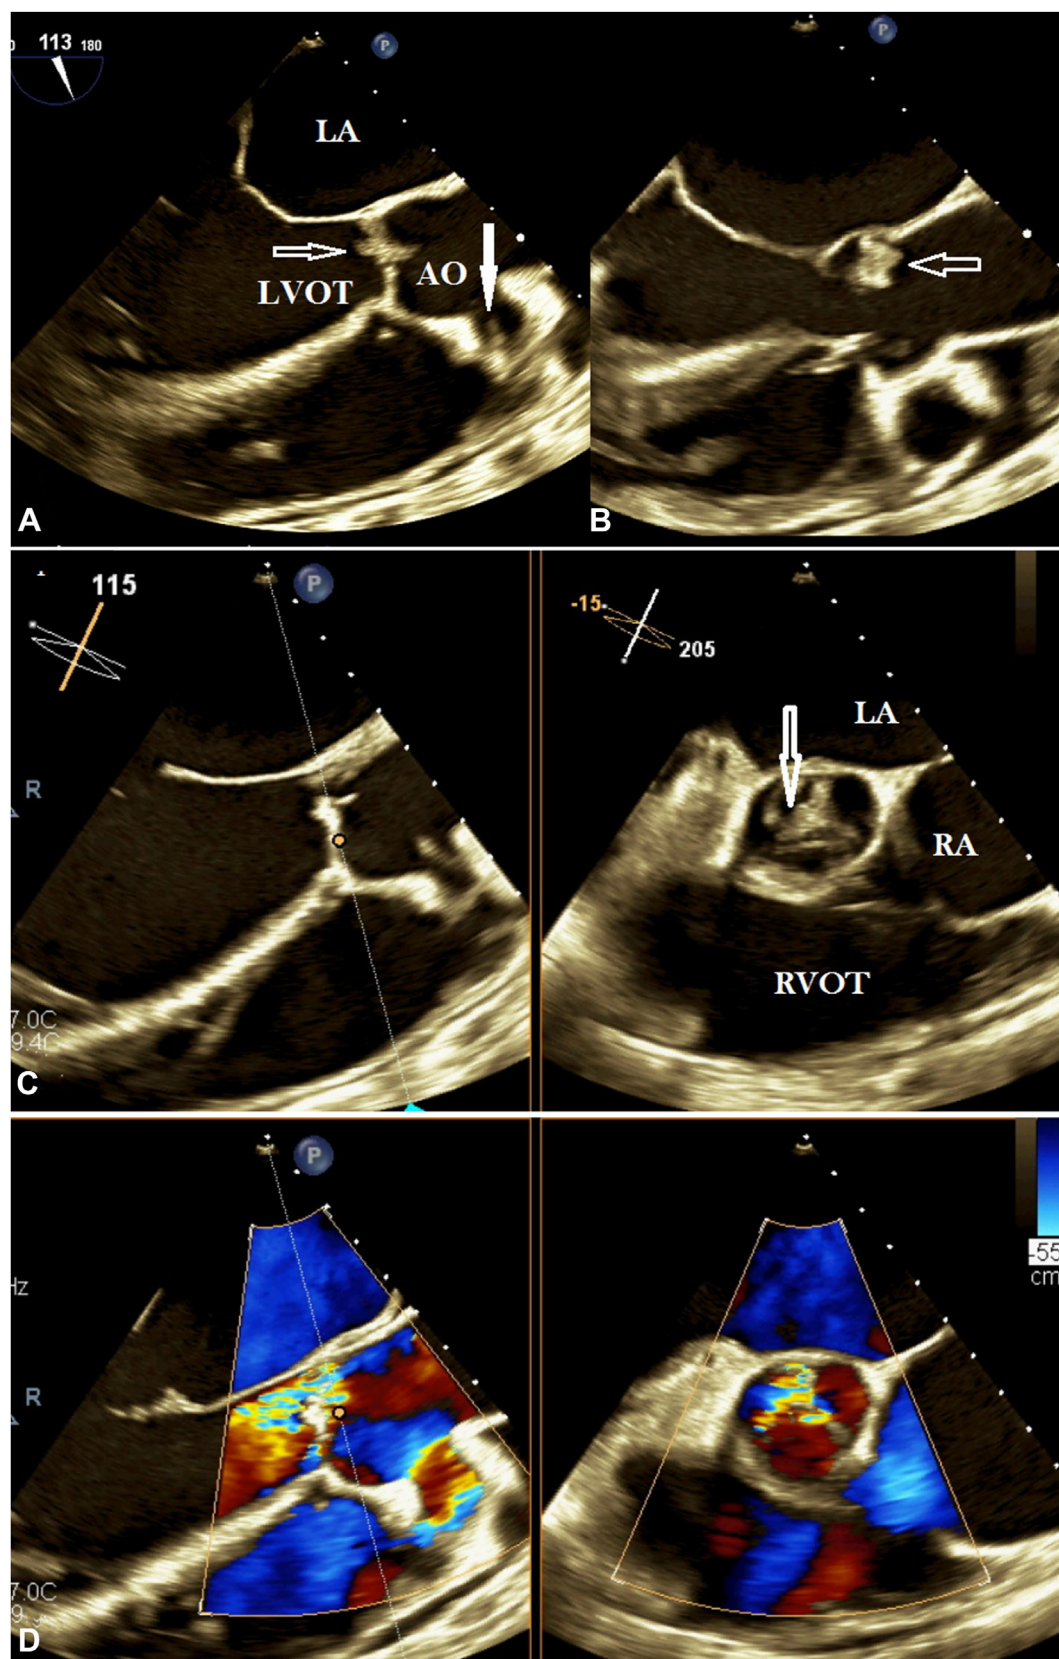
TEE, midesophageal long-axis (113°) diastolic (A) and systolic (B) views and simultaneous orthogonal long-axis (115°) and short-axis (−15°) diastolic views without (C,D) and with (E,F) color flow Doppler, demonstrates the vegetation (*open arrow*) on the noncoronary cusp of the damaged trileaflet AV and an echo-free space on the anteromedial side of the aortic root at the RCA ostium, representing the origin of the CAF (*solid arrow*), with a vegetation visible within it; moderate to severe AR is also seen. AO, Aorta; LA, left atrium; LVOT, left ventricular outflow tract; RVOT, right ventricular outflow tract.
